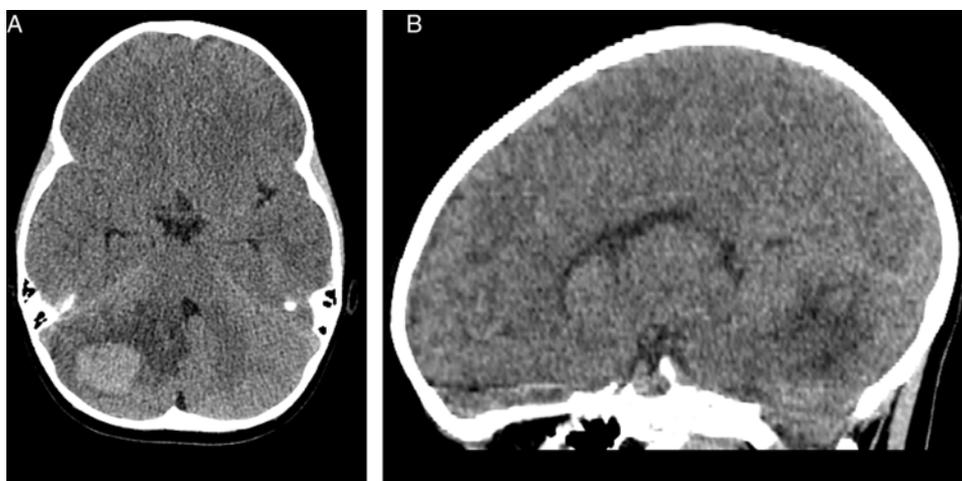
Axial noncontrast CT scan reveals a hyperdense mass in the right cerebellar hemisphere with moderate surrounding vasogenic edema causing effacement of the fourth ventricle (A) and right cerebellar tonsillar descent resulting in crowding of the foramen magnum (B).
